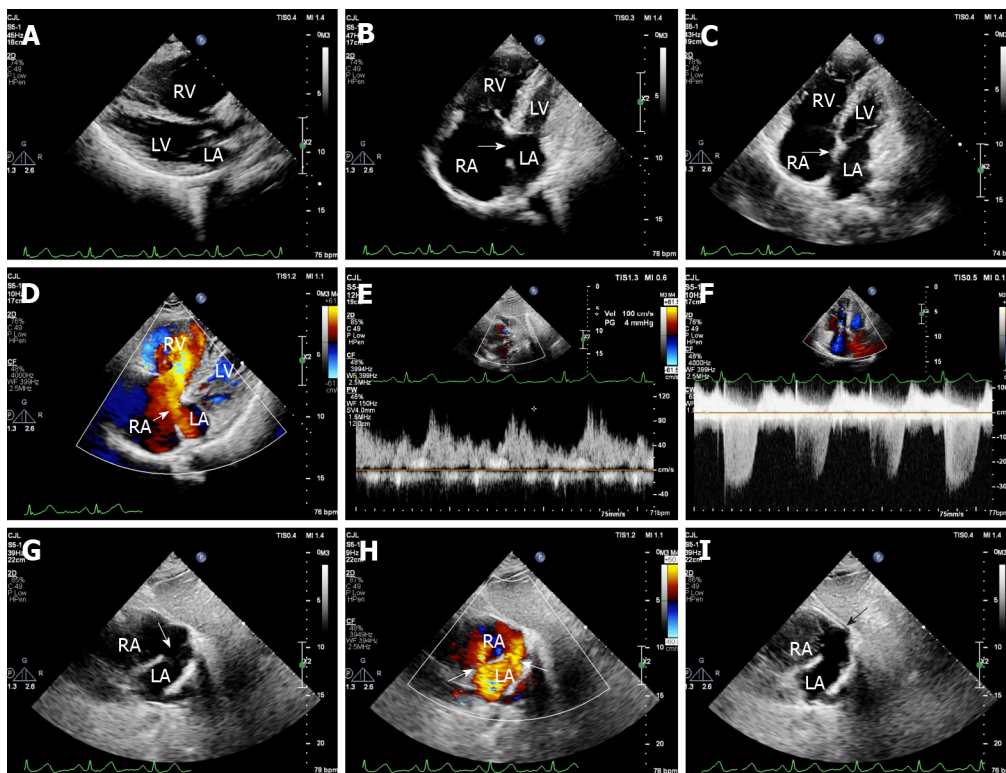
Transthoracic echocardiography before surgery. A: Significant enlargement of the right ventricle (anterior-posterior diameter = 43 mm); B: Location of the defect was near the endocardial cushions on apical four-chamber view, which was mistaken for a defect of the ostium primum atrial septal defect (ASD) (arrow); C: When detected on apical four-chamber view by scanning backward, a defect of the coronary sinus (CS) in the terminal portion and normal endocardial cushions were seen (arrow); D: A shunt through the defect of the CS in the terminal portion on apical four-chamber view (arrow); E: Pulse-wave Doppler spectrum showed a shunt during diastole through the defect of the CS in the terminal portion [V_{max} = 100 cm/s, pressure gradient (PG) = 4 mmHg]; F: Moderate-to-severe tricuspid regurgitation (V_{max} = 337 cm/s, PG = 45 mmHg, pulmonary artery systolic pressure = 50 mmHg); G: The defect of the CS in the terminal portion and secundum ASD on subxiphoid biatrial view (arrow, 3.3 cm \times 2.0 cm and 1.1 cm); H: Two shunts through the defect of the CS and secundum ASD on subxiphoid biatrial view (arrow); I: Negative filling was observed at the right atrium orifice of the CS and right atrium side of the secundum atrial septal by right-heart contrast echocardiography (arrow). RA: Right atrium; RV: Right ventricle; LA: Left atrium; LV: Left ventricle.
